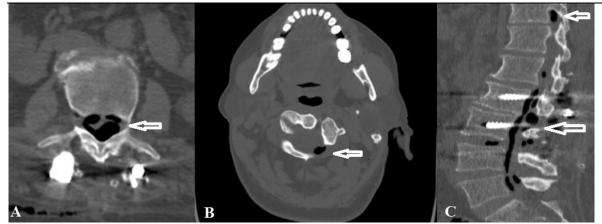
Post-operative axial (A,B) and sagittal (C) spinal CT findings showing pneumorrhachis.
